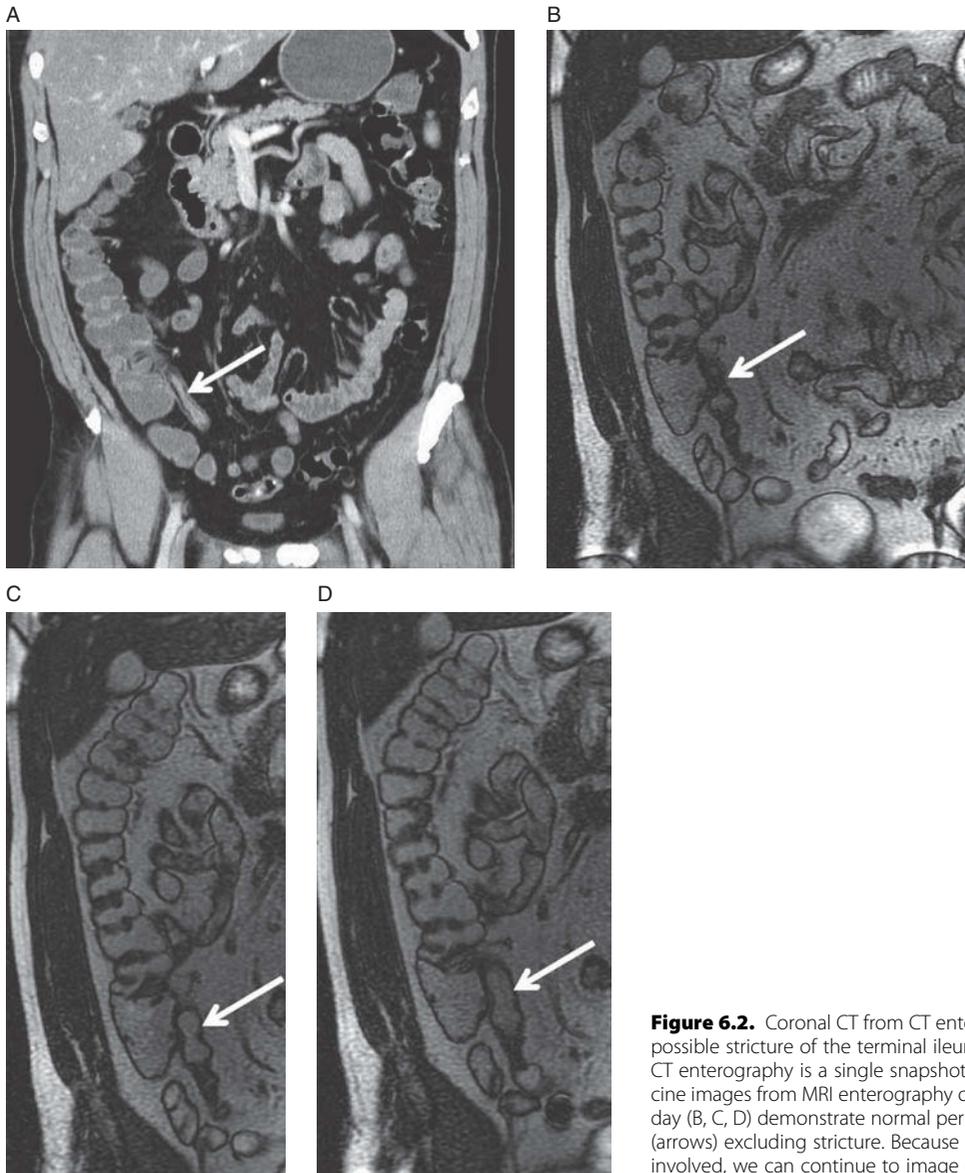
Coronal CT from CT enterography (A) demonstrates possible stricture of the terminal ileum (arrow). But, remember, CT enterography is a single snapshot in time. Coronal real-time cine images from MRI enterography of same patient on the same day (B, C, D) demonstrate normal peristalsis of the terminal ileum (arrows) excluding stricture. Because no ionizing radiation is involved, we can continue to image until we have our answer.
